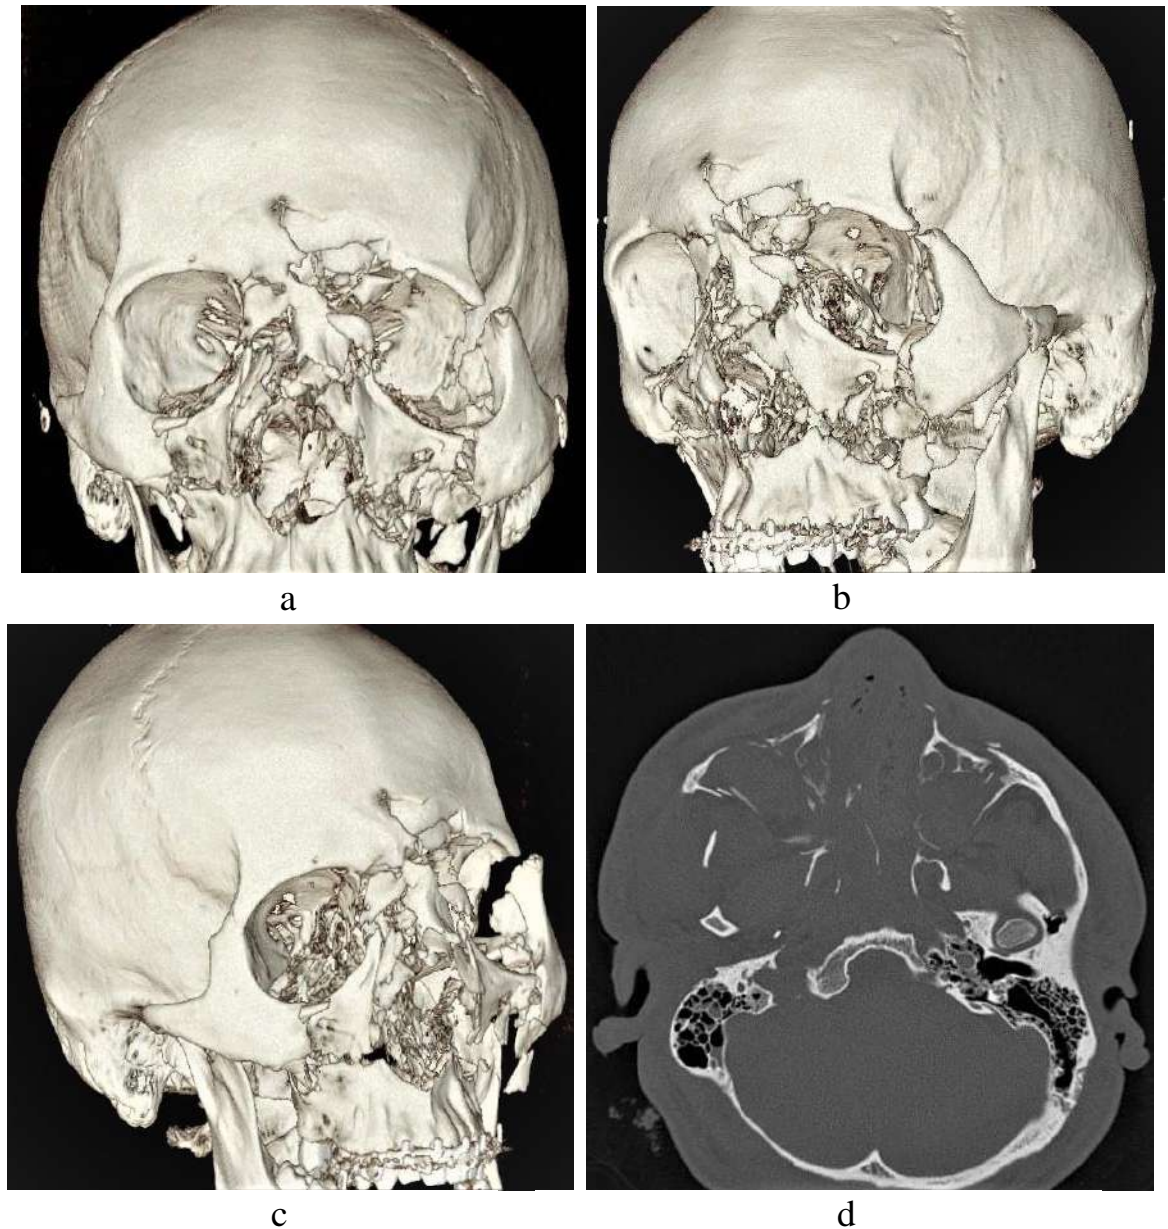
CT scan of the skull of the injured patient B., 26 years old, on the 3rd day after the injury: a) anterior view; b) left lateral view; c) right lateral view; d) coronal projection.
